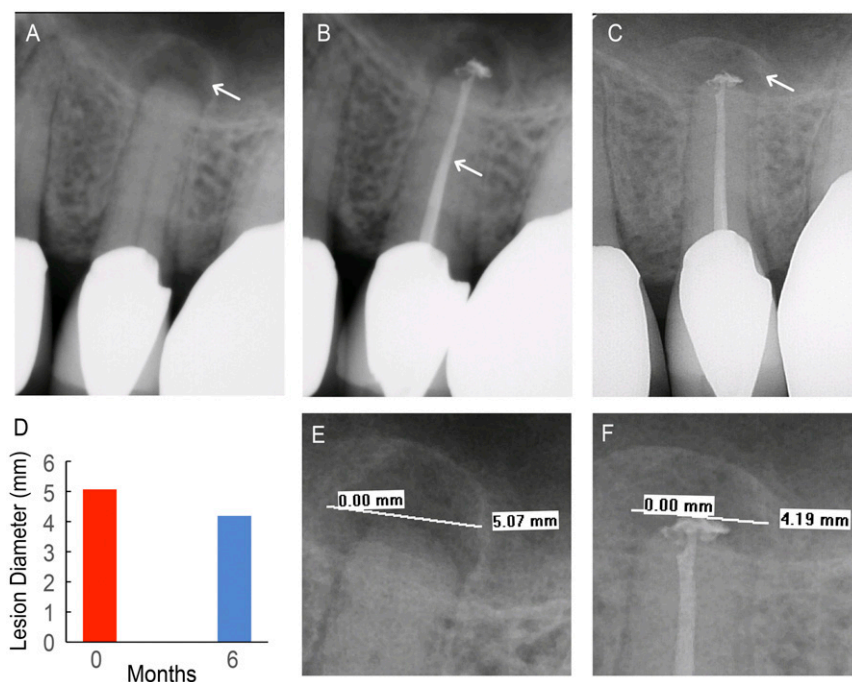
Control patient (C1). (A) Pretreatment radiograph of tooth 13 with existing apical lesion (white arrow). (B) Completed backfill (white arrow) and apical seal with unmodified GP. (C) Six-month follow-up radiograph shows the apical lesion with increased bone density (white arrow). (D) Lesion diameter at pretreatment (red) and 6-mo follow-up (blue) appointments. (E) A 5.07-mm apical lesion diameter was visible on the pretreatment radiograph. (F) A 4.19-mm apical lesion diameter was visible on the 6-mo follow-up radiograph.
